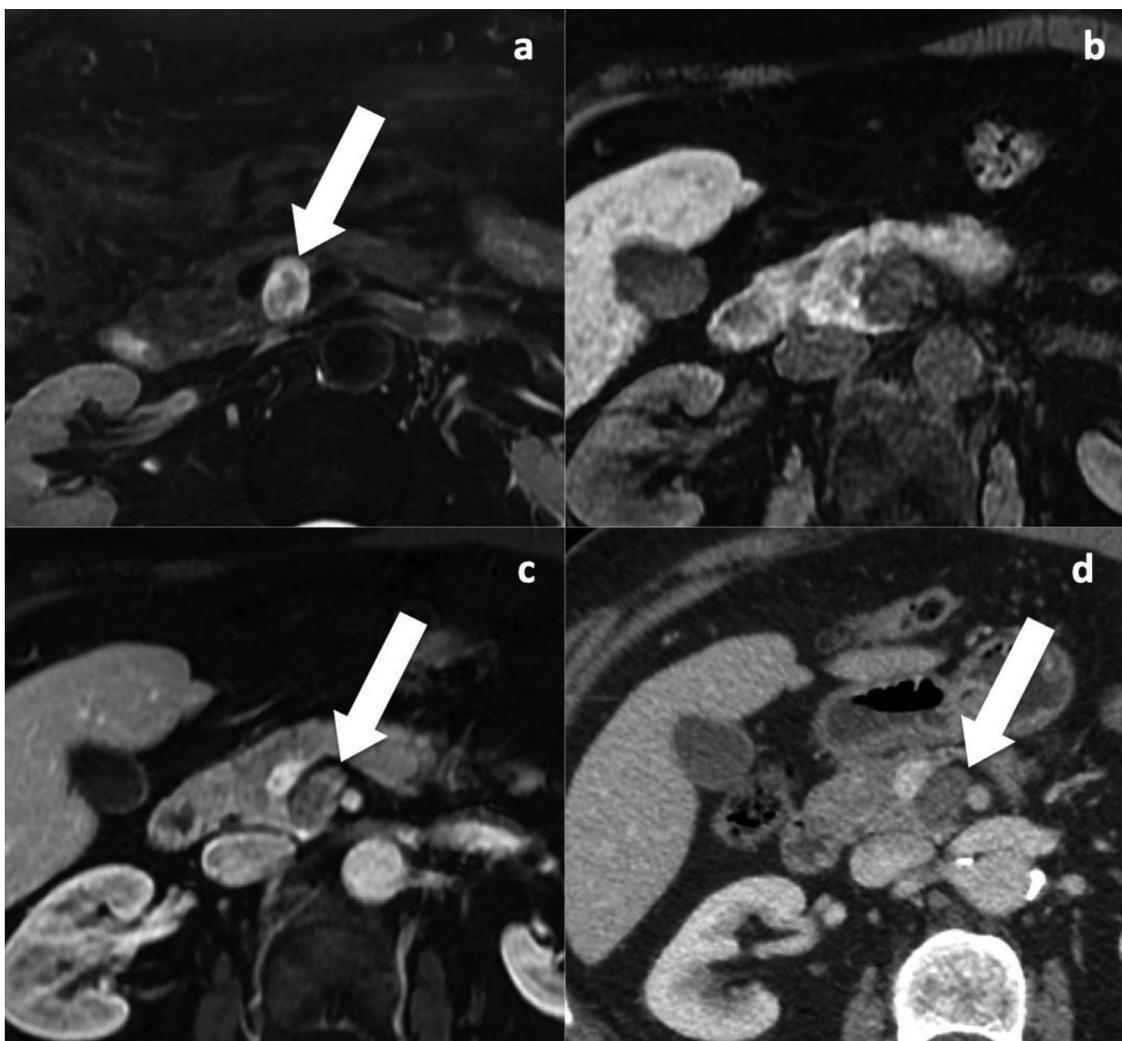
Pancreatic schwannoma in a 73-year-old male patient. Fat-suppressed T2-weighted MR image (a) shows a hyperintense lesion of the pancreatic head (arrow). The lesion is well delineated and hypointense on precontrast fat-suppressed T1 GRE MR image (b) and shows mild-moderate enhancement on enhanced fat-suppressed T1 GRE MR image (c) and on contrast-enhanced CT image obtained during the portal venous phase (d).
